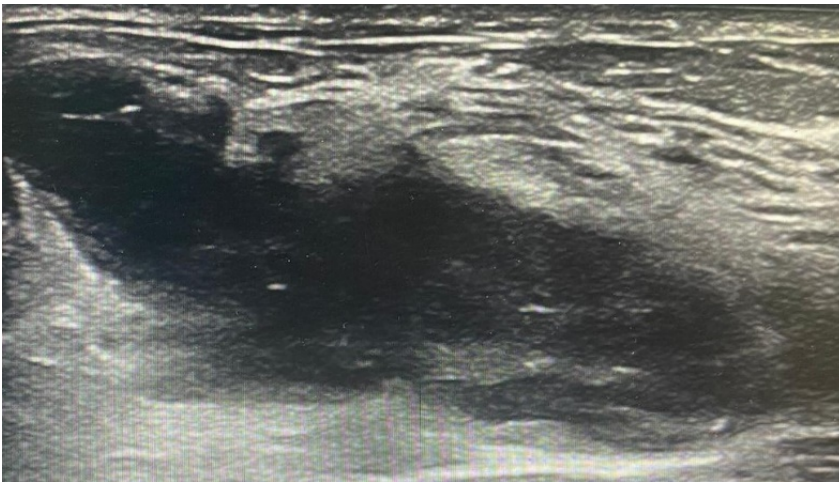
Ultrasound shows extensive hypo-anechoic formation.
